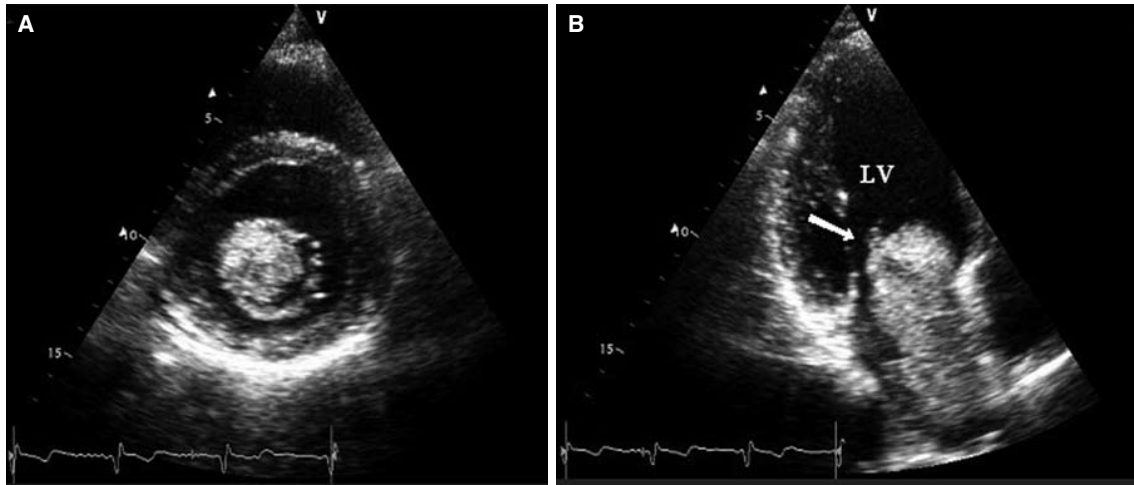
(A) Myxoma obstructing the mitral valve during diastole in the parasternal short-axis view. (B) The apical four-chamber view showing myxoma protruding through the mitral valve into the left ventricle.
